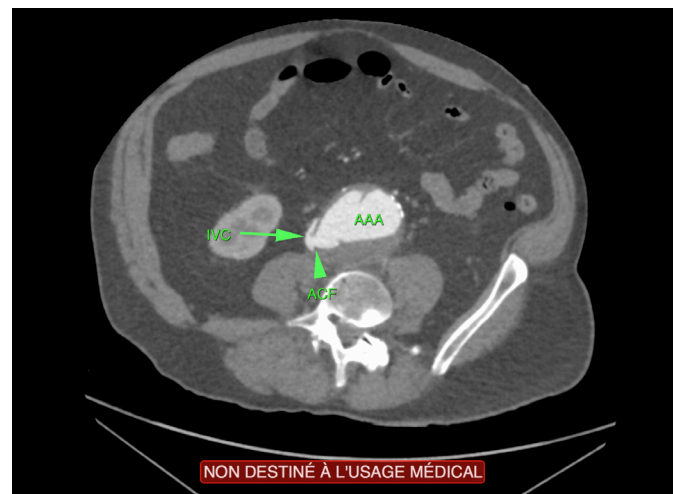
CT-scan image of aorticaval fistula (axial view) ©NCazes
